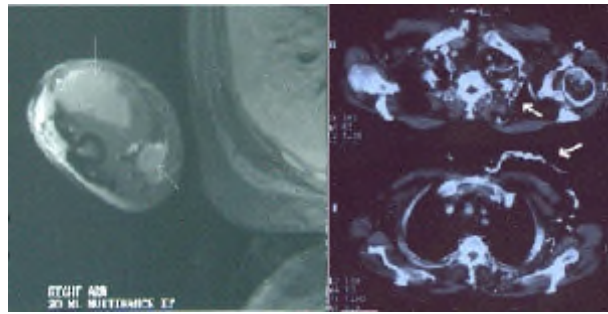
Left: MRI of the right arm showing two soft tissue masses (arrows).
